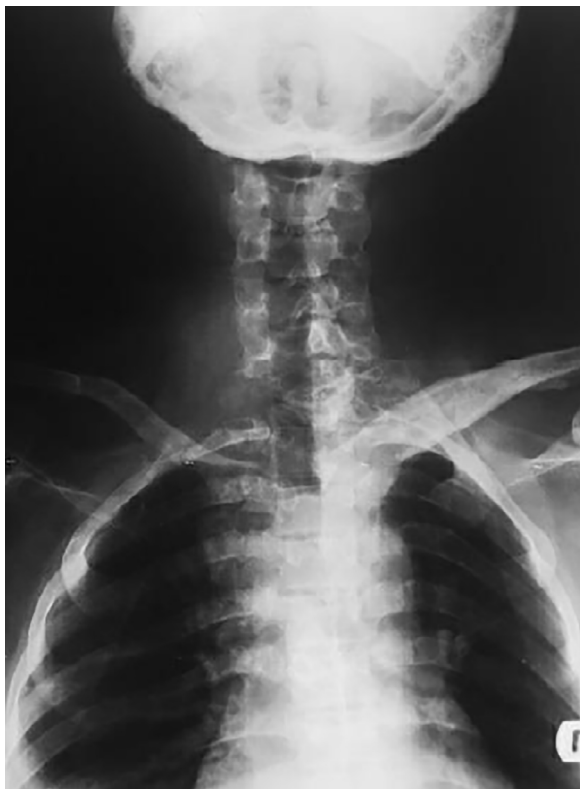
Anteroposterior radiograph of the spine showing the bone destruction in the C7-T1 region
